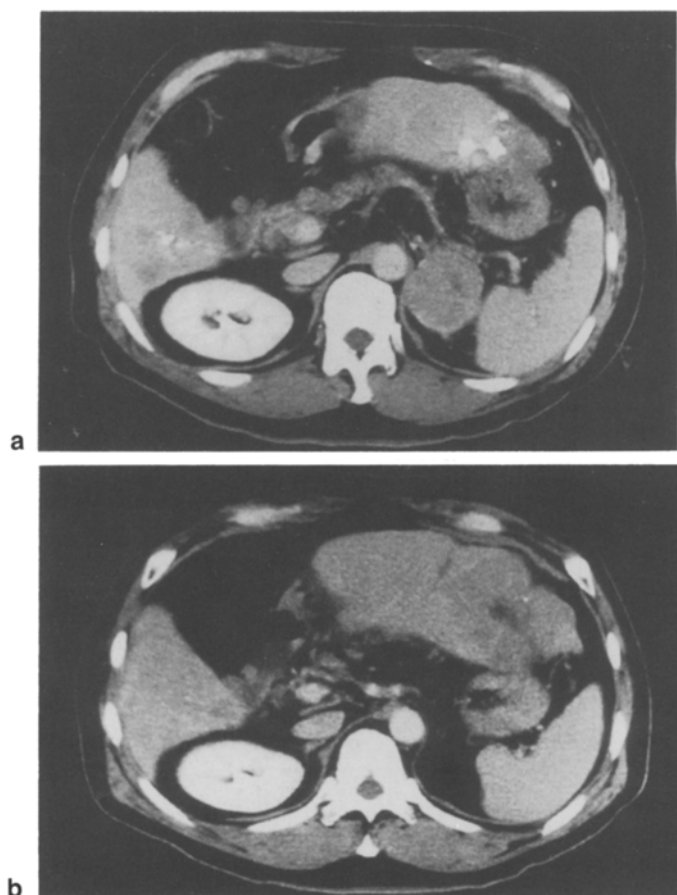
Abdominal CT scan findings of an unresectable patient with multiple HCC before and after TIE therapy. a Before TIE therapy. b At 3 months after TIE therapy. The tumors in S2 and S8 have become lower in density and decreased markedly in size after TIE therapy
